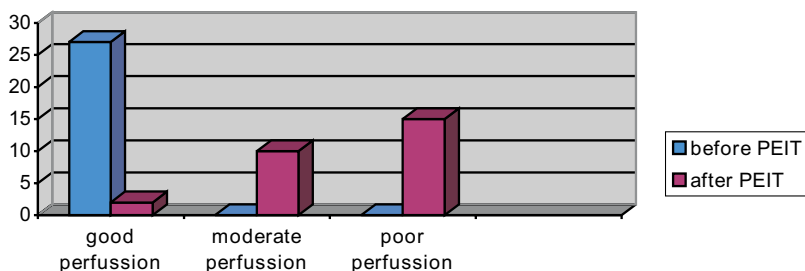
Assessment of tumor perfusion (CT scan / angiography) before and after PEIT.
